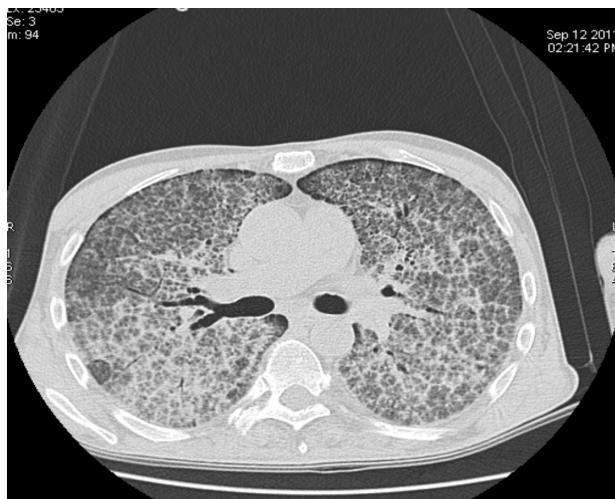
CT scan imaging showed “crazy paving” appearance and interlobular septal thickening.
